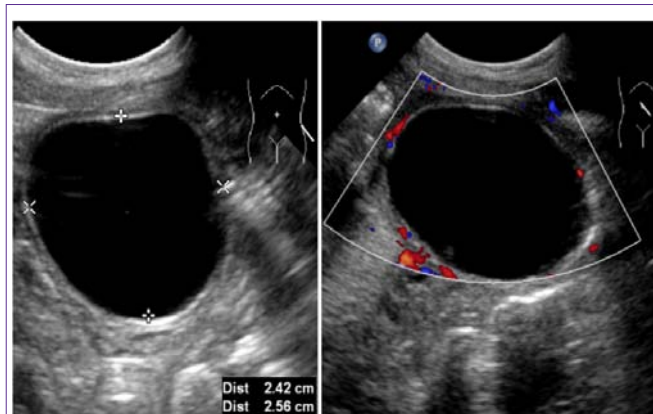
Postnatal ultrasound scan and colour Doppler- Note double lining of enhancing intestinal mucosa and simple cyst less than 5 cm in diameter.
